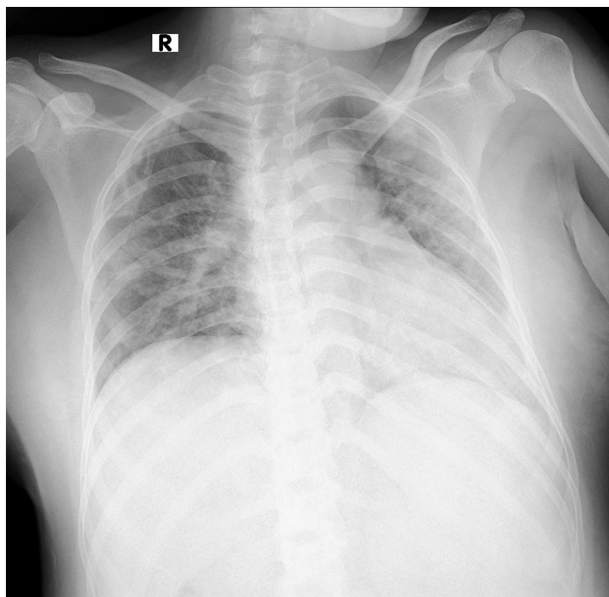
Chest X-ray taken on hospital day 13.
